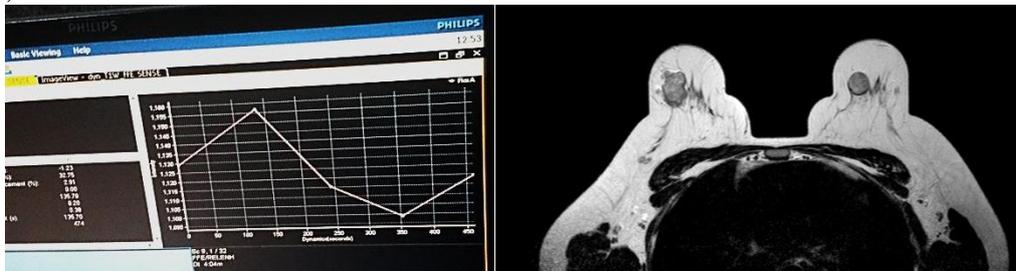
(DCE-MRI " type 3 kinetic curve ") non contrast MRI. Bilateral breast cancer in T2 WI . both show type 3kinetic curve
